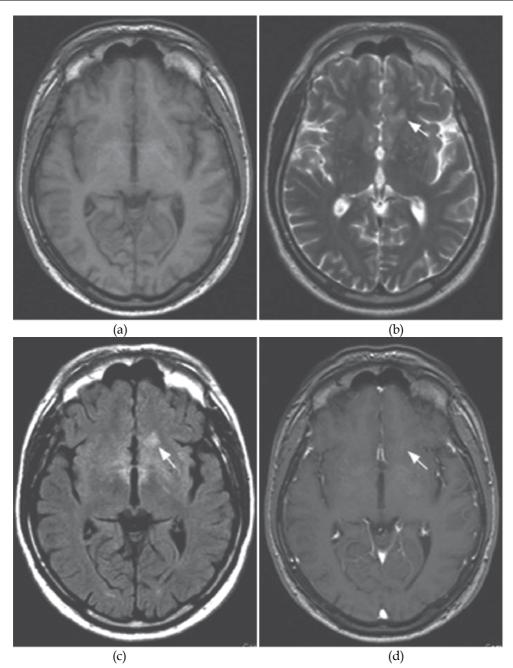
A 40-year-old male with memory loss, confusion, disorientation and multisystemic sarcoidosis. (a) Axial T1-weighted MR image at the level of the basal ganglia is unremarkable. (b) Axial T2 and (c) axial FLAIR images show areas of increased signal intensity within the white matter of the medial frontal lobes, left being greater than right. (d) Axial gadolinium-enhanced image shows minimal enhancement in the medial frontal lobes.
